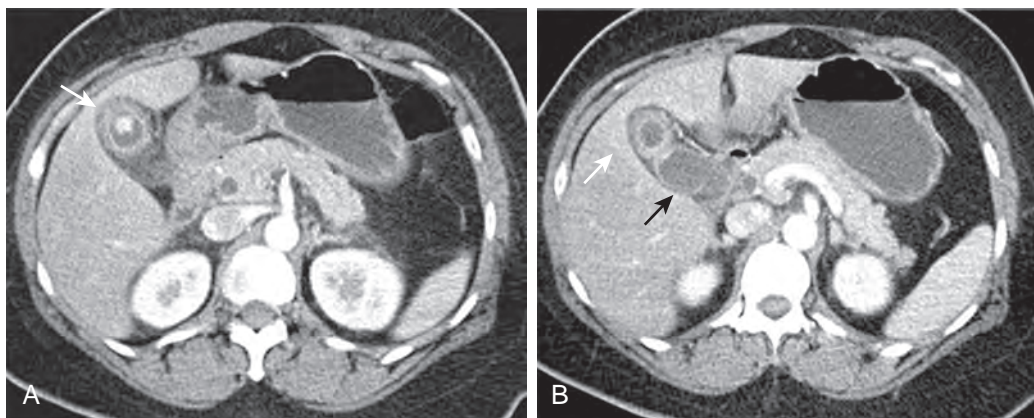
Segmental adenomyomatosis with associated acute cholecystitis. A. Contrast-enhanced CT demonstrates focal gallbladder wall thickening and stone in the fundal compartment (*arrow*). B. There is hyperemia in the adjacent liver, compatible with active inflammation, helping to confirm diagnosis of acute cholecystitis (*white arrow*). The inferior portion of the gallbladder demonstrates normal wall thickness (*black arrow*).
